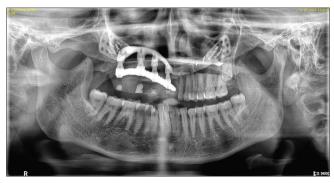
Post operative orthopantomogram (OPG) showing fixation of patient specific implant with rigid fixation screws along with the prosthetic components
